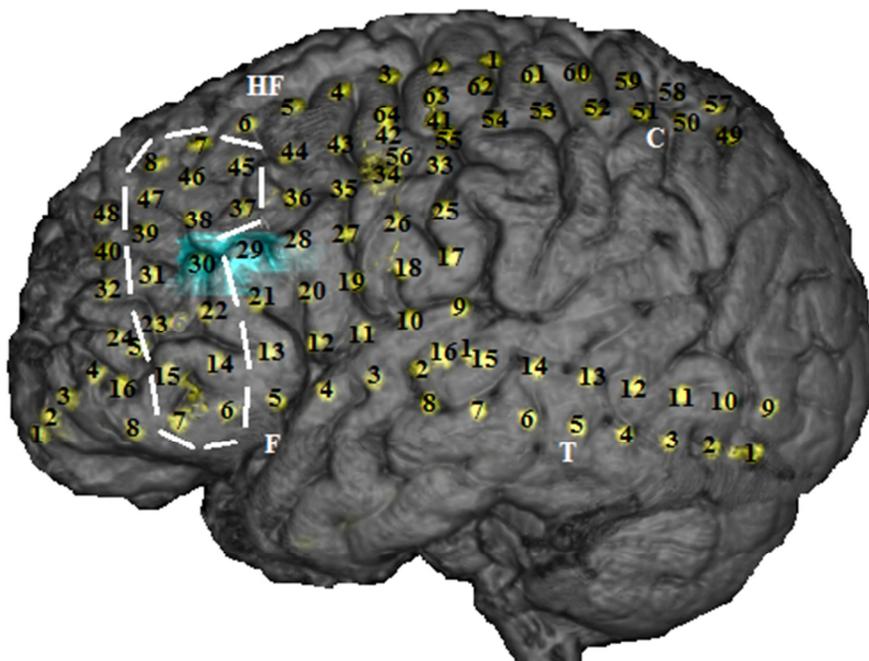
MRI of patient N.V. before the neurosurgical intervention with numbers and locations of the temporarily implanted electrodes. The area within the dotted line has been removed during the resection.
